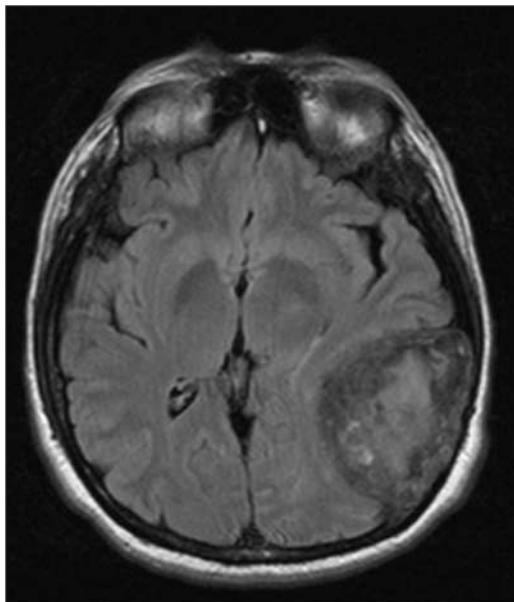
MRI of a large intracranial cholesterol granuloma complicating homozygous familial hypercholesterolemia.
